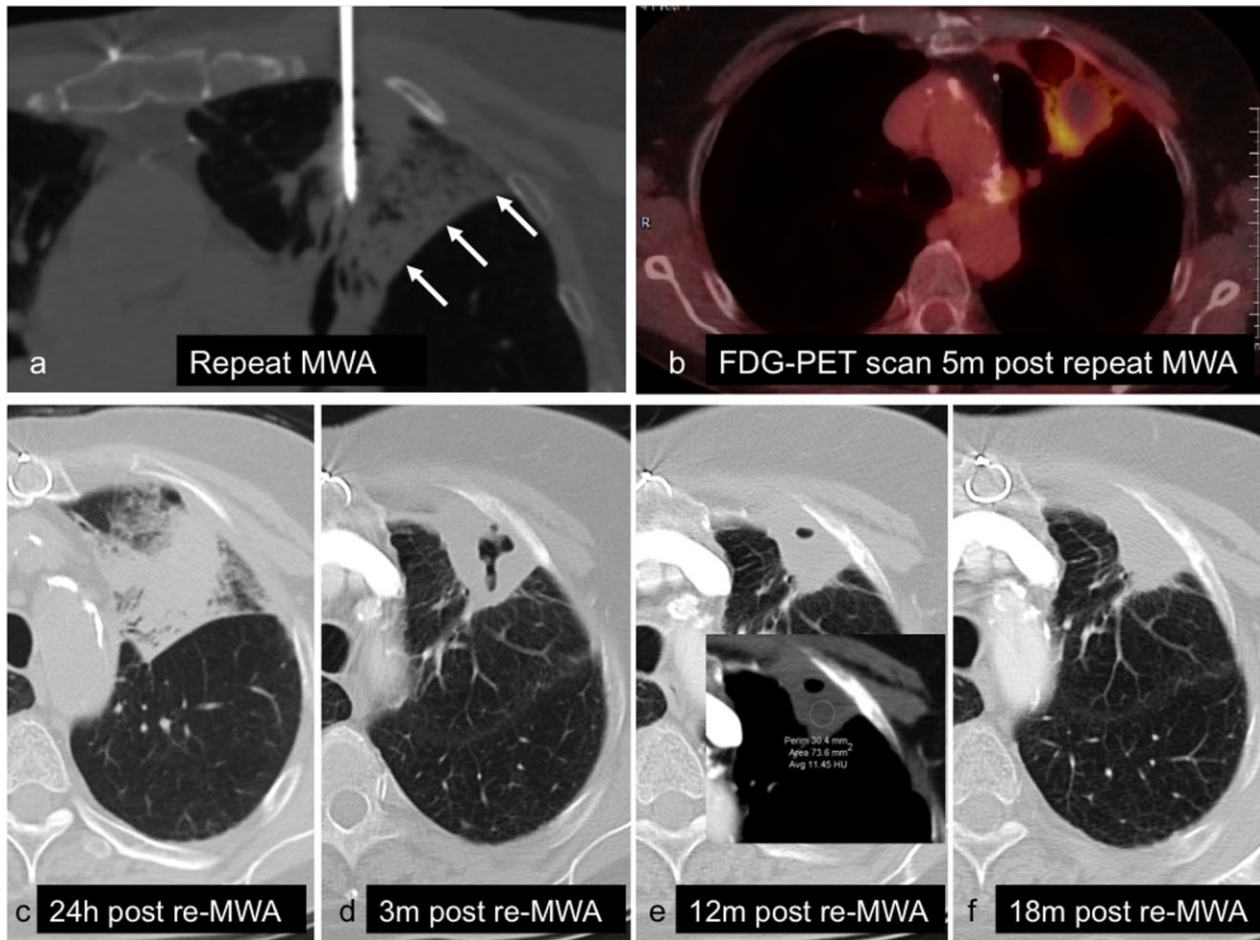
Seventy-five-year-old female with microwave ablation (MWA) of local recurrence post-radical external beam radiation (XRT) for left upper lobe T1N0M0 non-small cell lung cancer (NSCLC). (a) Repeat CT-guided MWA, axial plane. Intra-procedural haemorrhage (arrows) (b) fludeoxyglucose (FDG)-positron emission tomography (PET) scan 5 months post-repeat MWA shows residual medial uptake deemed equivocal. (c–f) Axial CT scans between 24 hours and 18 months post-re-ablation show gradual shrinkage of the ablated focus; tissue density of 11 HU on the 12-month scan (inset) reflects no residual enhancement.
